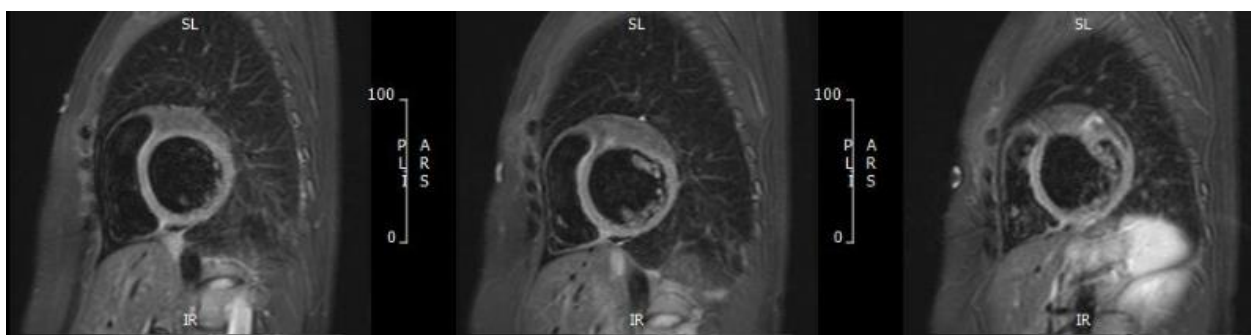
The turbo spin echo T1-weighted image with fat saturation sequences in the left ventricular short-axis plane reveals a thick stripe of subepicardial low-signal intensity at the anterior left ventricular wall.
